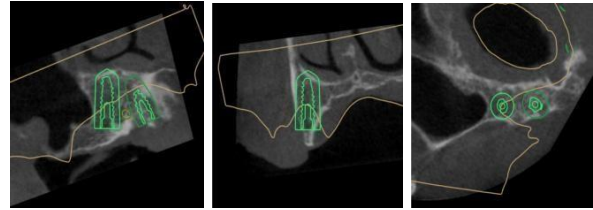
CBCT with Implant site planning using MGUIDE
